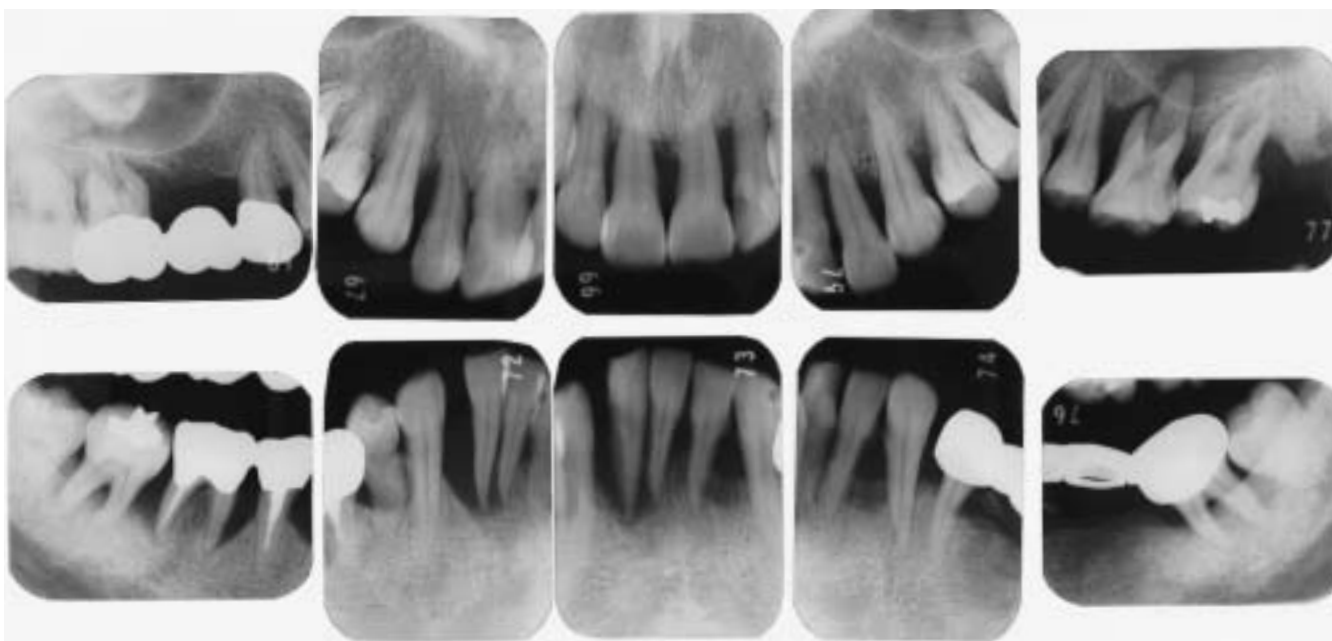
Radiographic series taken at her first visit (1982). Note the extensive furcation involvements and complete loss of bone around the mandibular incisors. These teeth seemed to be no longer salvageable.
